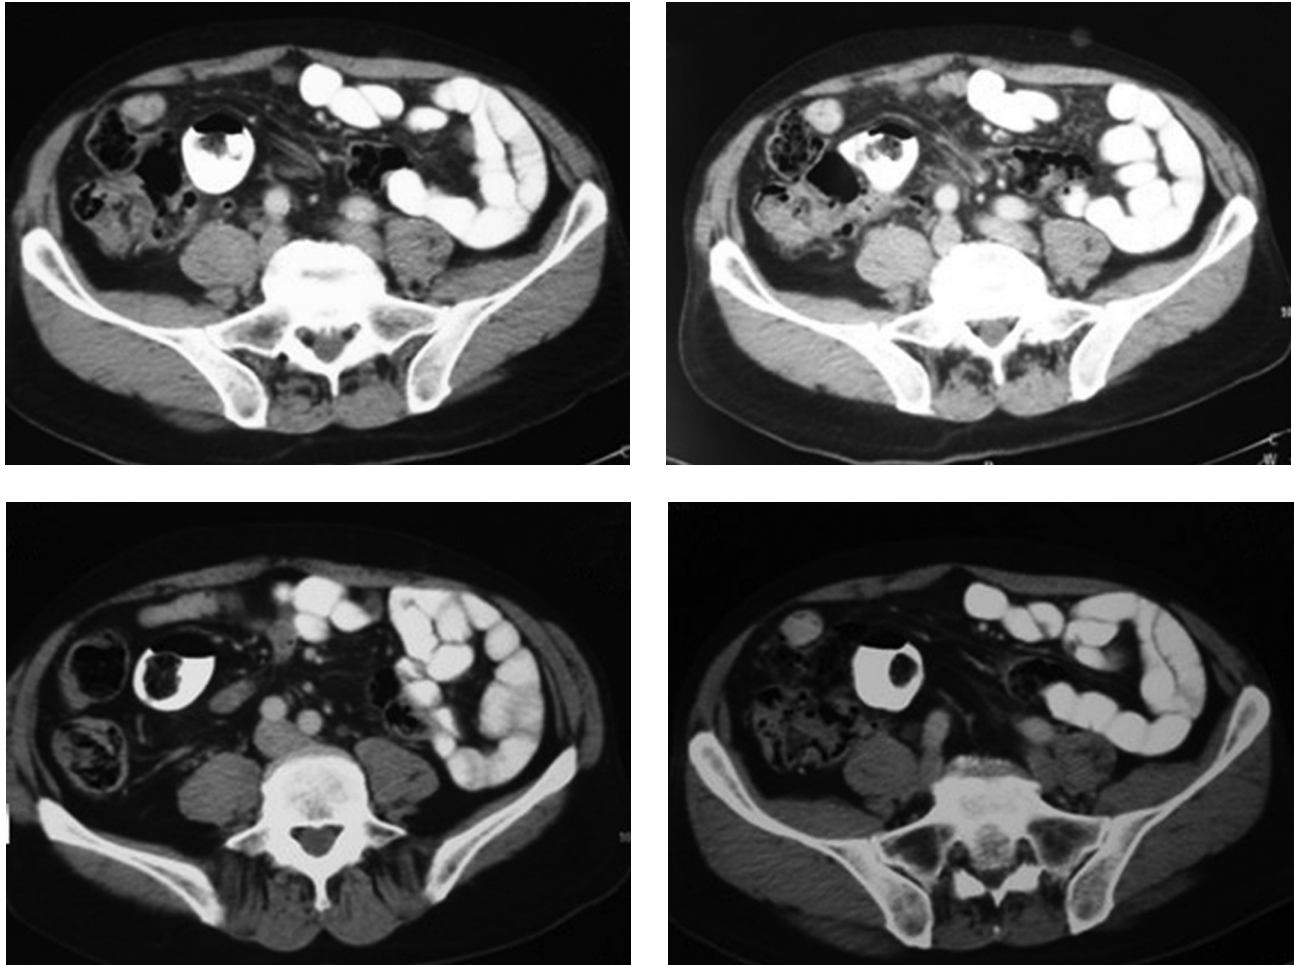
10 days after discharge intramural hematoma resolved on abdominal CT.
